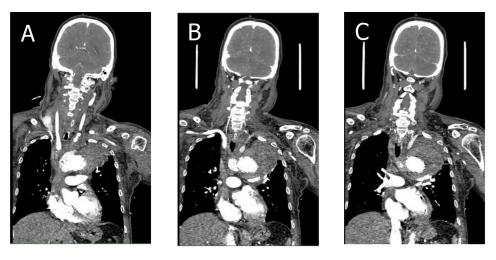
Radiographic feature of endoleak type IA, A., B., C. CTA shows contrast leakage at the proximal aortic stent. D. CTA with 3D reconstruction shows an endovascular aortic stent- graft at the aortic arch, just at the level of the origin of the left common carotid artery cover to the middescending thoracic aorta. E. CTA with the 3D reconstruction of the same patient, posttreatment for 6 months, demonstrated a new stent-graft at the aortic arch, inner to the previous stent, and covering more on the descending thoracic aorta. Note the stent-graft at the abdominal aorta.
